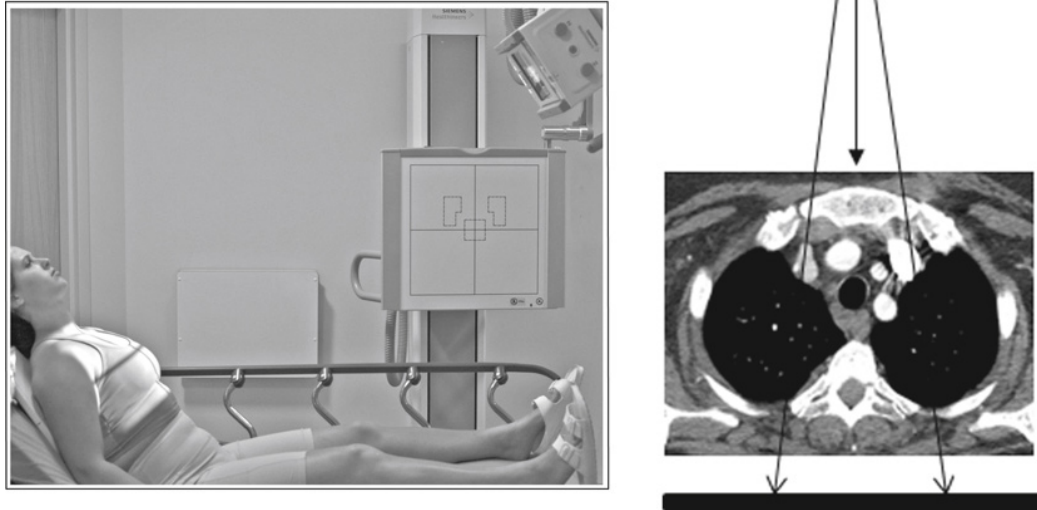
Proper patient positioning for an AP chest projection. The axial CT slice was obtained at a level where the manubrium and sternal clavicular ends connect. When the patient is in an AP projection and the CR is perpendicular to the transverse axis of the IR and midcoronal plane, the sternal clavicular ends are at equal distances from the vertebral column.
